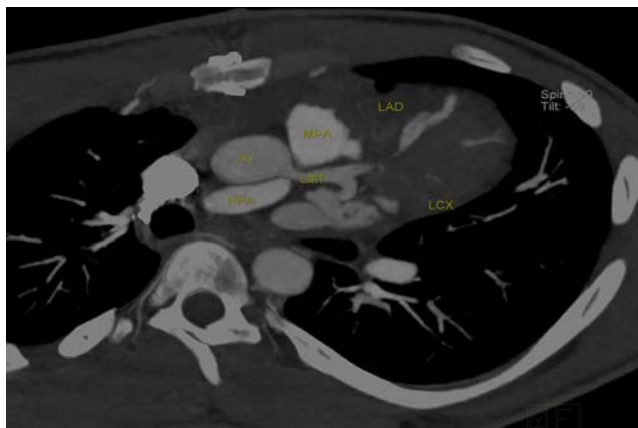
(b). Postoperative axial CT scan showing the origin of LMCA from the aorta after its re-implantation.
